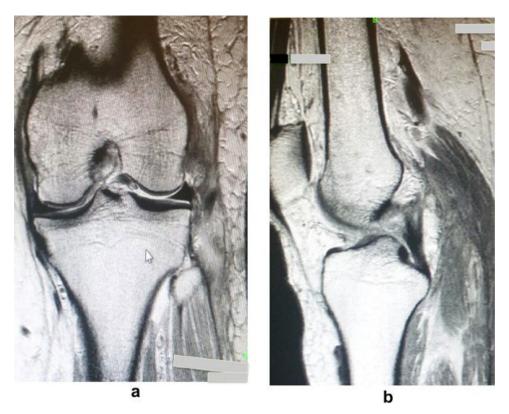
(a) Magnetic Resonance Imaging (MRI); T2 weighted coronal image showing posterolateral corner structures tear. (b) MRI T2 weighted sagittal image showing the anterior cruciate ligament rupture and Lateral meniscal tear.
